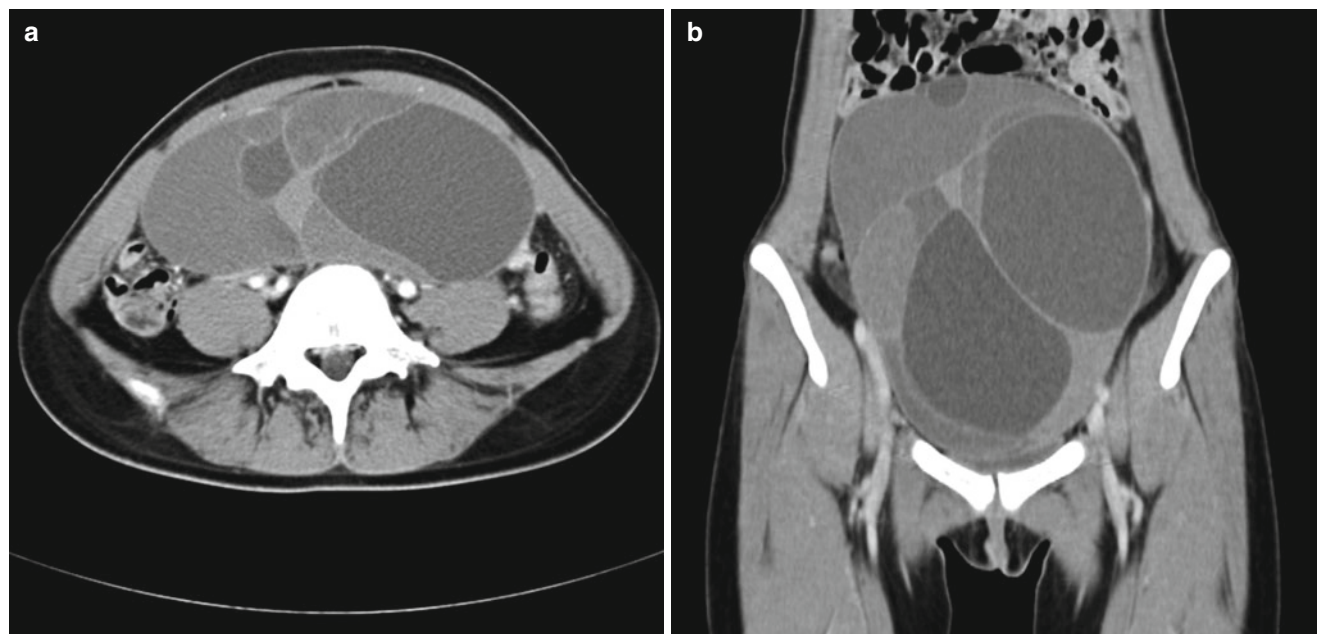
Mucinous cystadenoma in a 18-year-old girl. Contrast-enhanced axial (a) and coronal (b) CT scans show multiseptated, huge cystic mass in abdomino-pelvic cavity. Note that the locules of the mass have different attenuations
